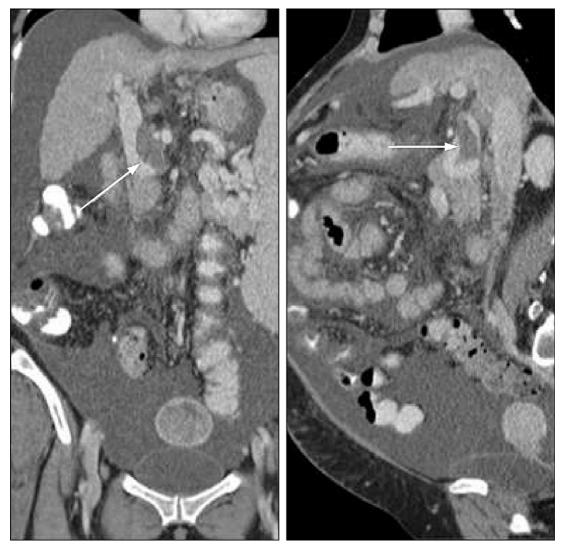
The coronal and sagital view of a contrast enhanced CT in a 50-year-old female patient shows partial obstruction of the portal vein. The white arrow indicates narrowing and partial obstruction due to a huge thrombosis located in the extrahepatic portal vein.
